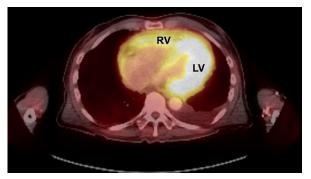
Positron emission tomographic/computed tomographic scan shows infiltrative myocardial thickening with increased metabolic activity in both ventricles (most pronounced in the left ventricular [LV] lateral wall), as well as increased nodularity adjacent to the pericardium and in the subepicardial region overlying the right ventricle (RV).
